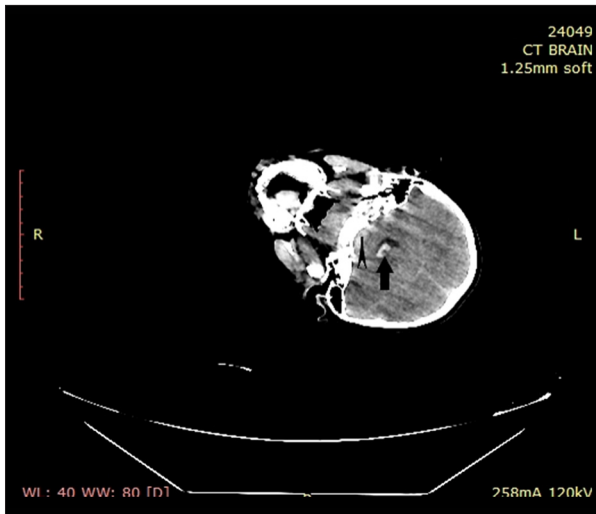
Initial CT scan, showing the thrombus within the fourth ventricle, as well as blood accumulated within the basal cisterns anterior to the brainstem. CT – computed tomography.
